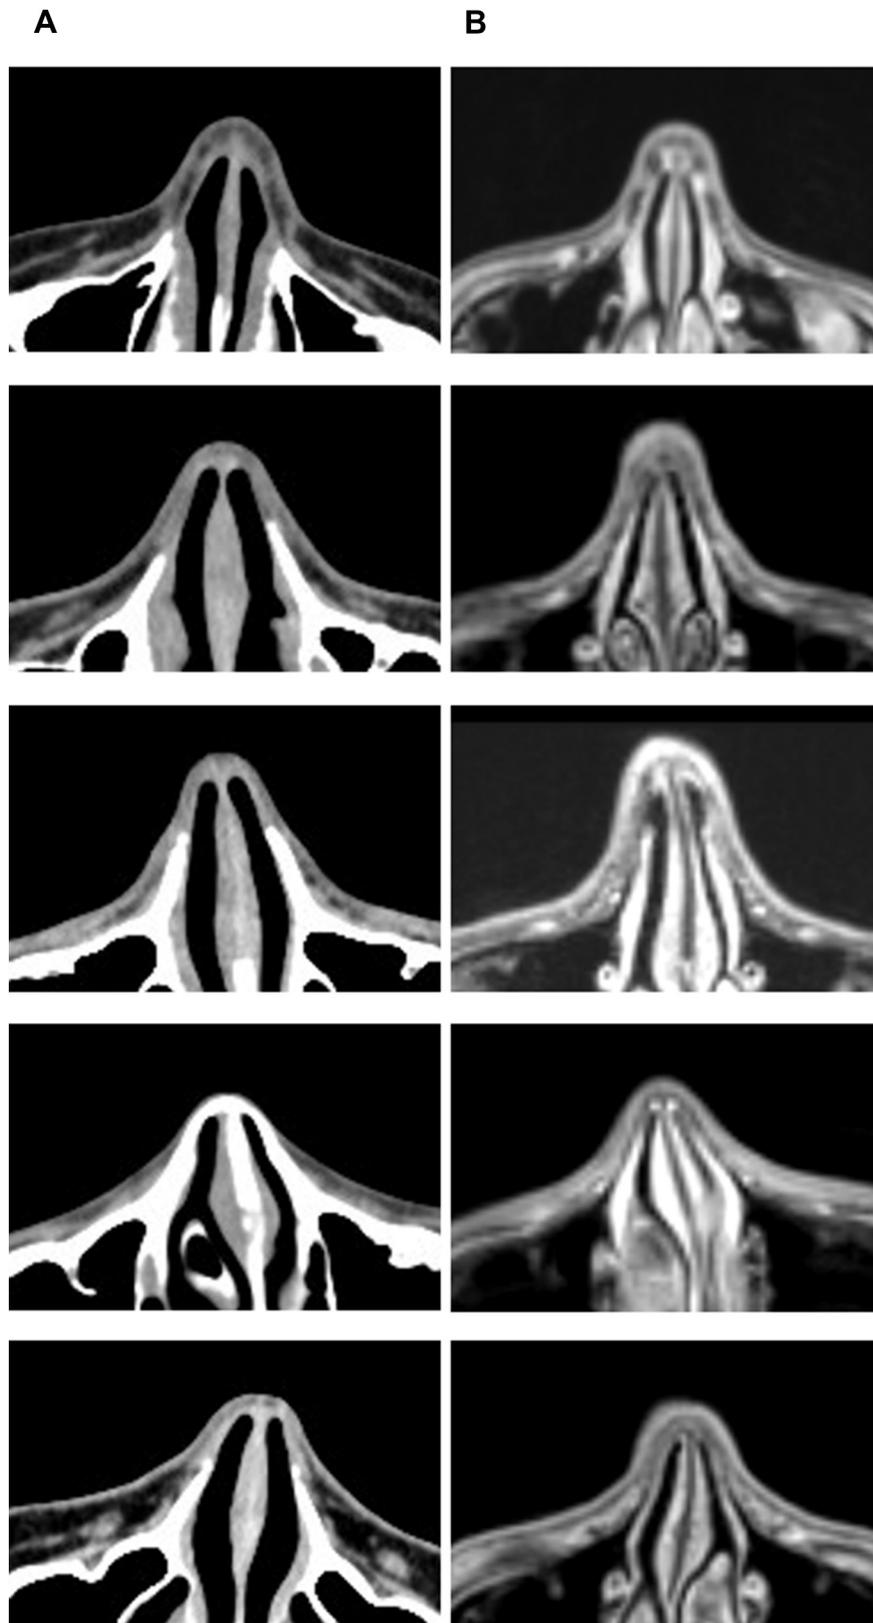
Comparison of surface contrast in CT versus 3.0-T MRI in five patients. A) Thin layer CT scan for laser scan based surface registration. B) 3.0-T planning MRI scan, the surface of the MRI scan is less even, compared to the CT surface.
